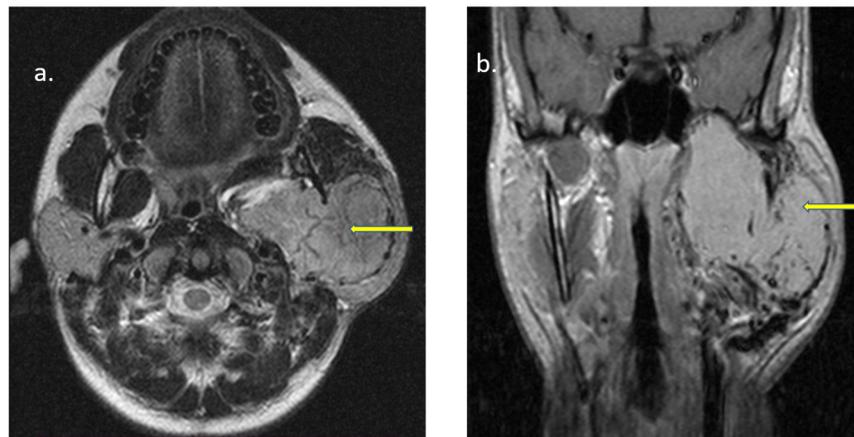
MRI Base of skull to root of neck (a)T2 WI showing a lobulated heterogeneously hyperintense lesion in left parotid gland with internal flow voids suggestive of internal vessels, (b)T1WI post contrast, showing significant post contrast enhancement
